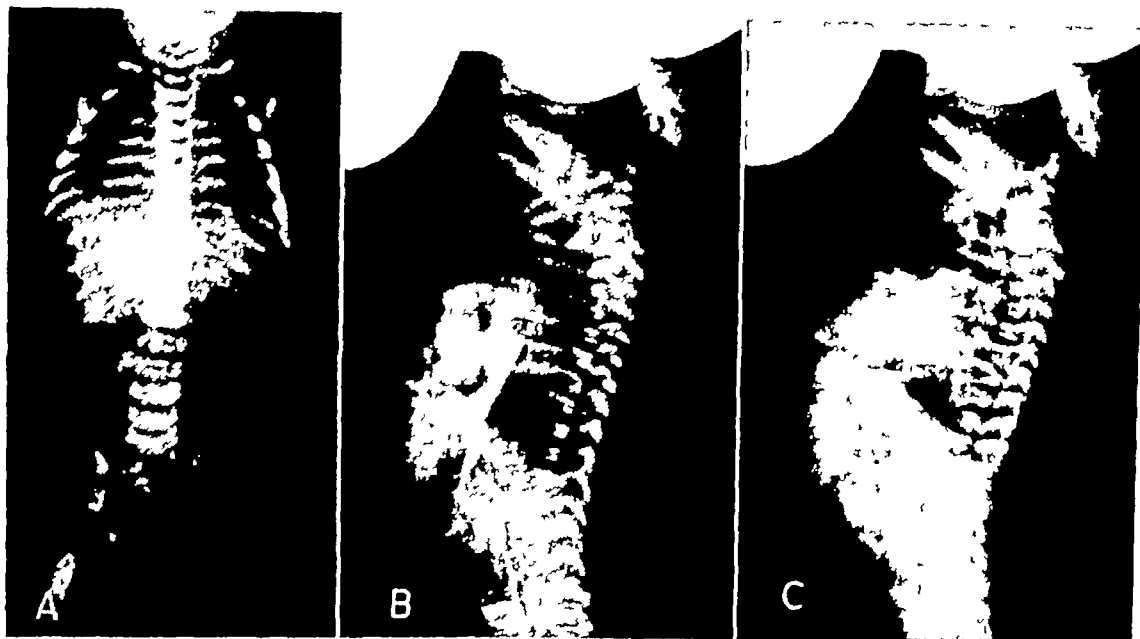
Angiocardiographic demonstration of communication of left ventricle with mass in author's case K W. A, Posteroanterior roentgenogram prior to injection. B, Lateral roentgenogram obtained early after injection of contrast medium. Note filling of right ventricle. C, Later serial roentgenogram showing opacification of left ventricle and mass (Bailey, C P. *Surgery of the Heart*. Lea & Febiger, Philadelphia, 1955, Ed 1)
